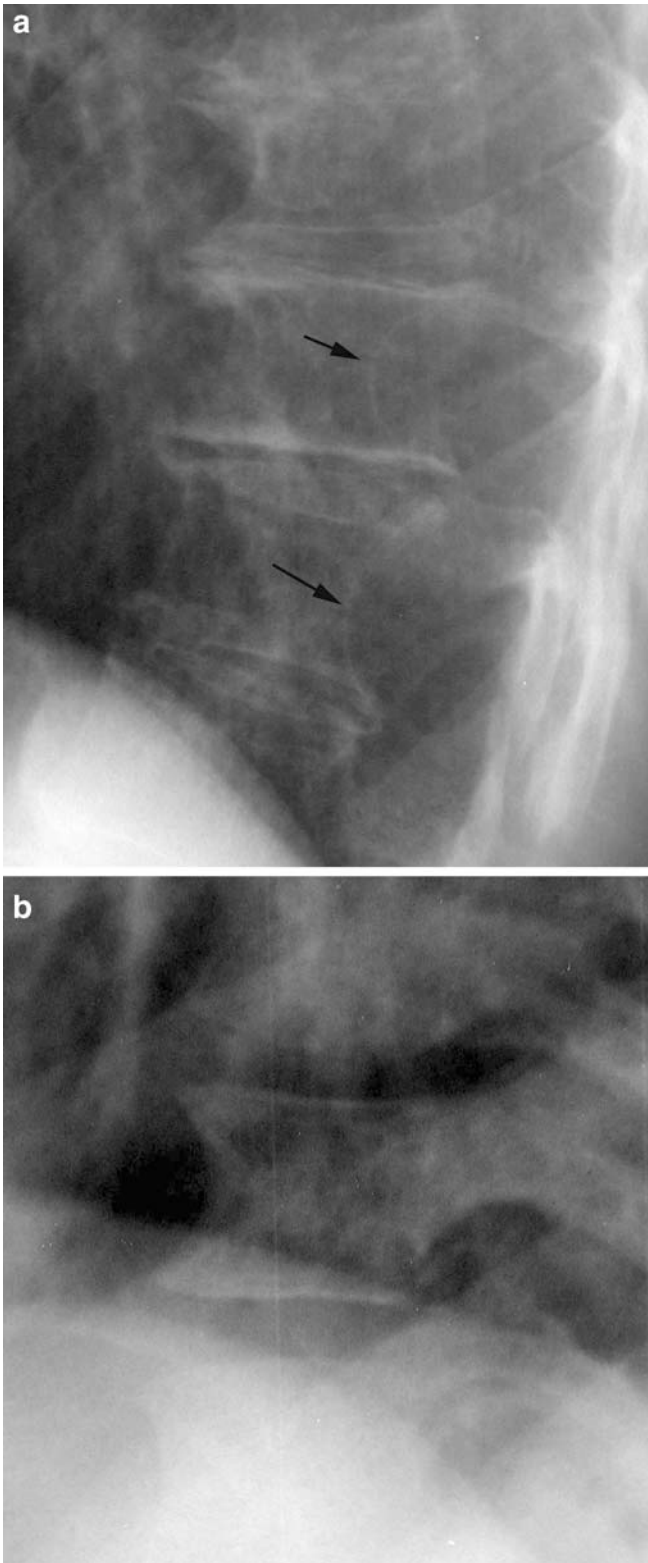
Vertebral scalloping in NF-1. a Lateral coned radiograph of the lower thoracic spine demonstrating posterior vertebral scalloping (*arrows*). b Lateral coned radiograph of the lower thoracic spine demonstrating anterior vertebral scalloping
